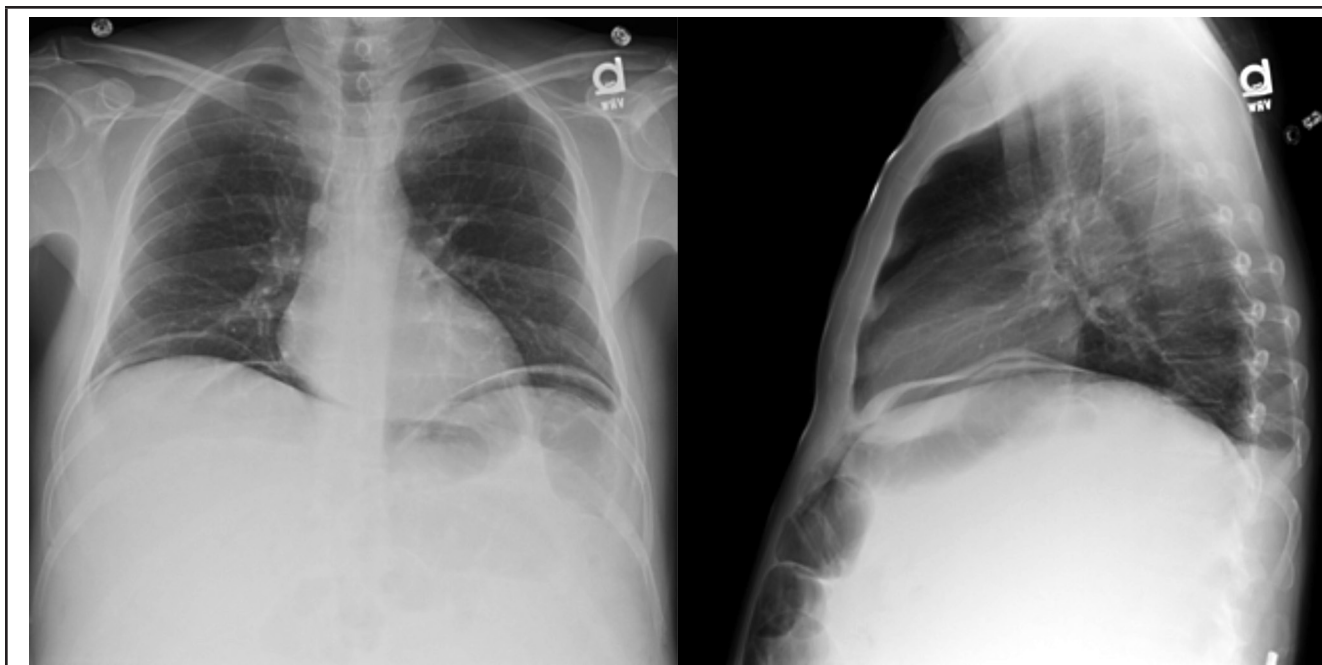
Chest x-ray upright in PA and lateral views on the first day of admission showed free air under diaphragm.
